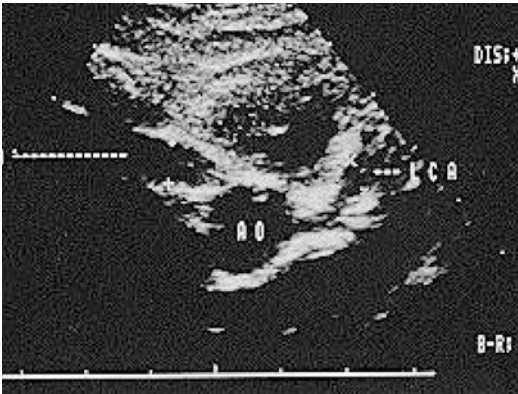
Aneurysm of coronary artery (echocardiogram)
